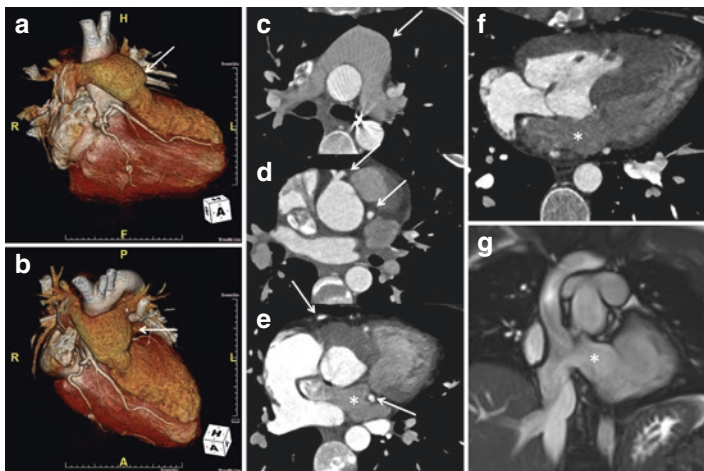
Repaired TGA with double switch and LeCompte maneuver. Volume rendered images (a, b) provide 3D assessment of the post-surgical anatomy; the pulmonary artery and its branches are seen in front of ascending aorta (a–c). CT is specially suited for the evaluation of reimplanted coronary arteries (d, e; *arrows*). Cardiovascular CT is helpful for the assessment of atrial inflow patency (e, f; *asterisks*). Oblique coronal SSFP image (g) also shows the patency of atrial baffle and vena cavae (better seen on cine; gif)
